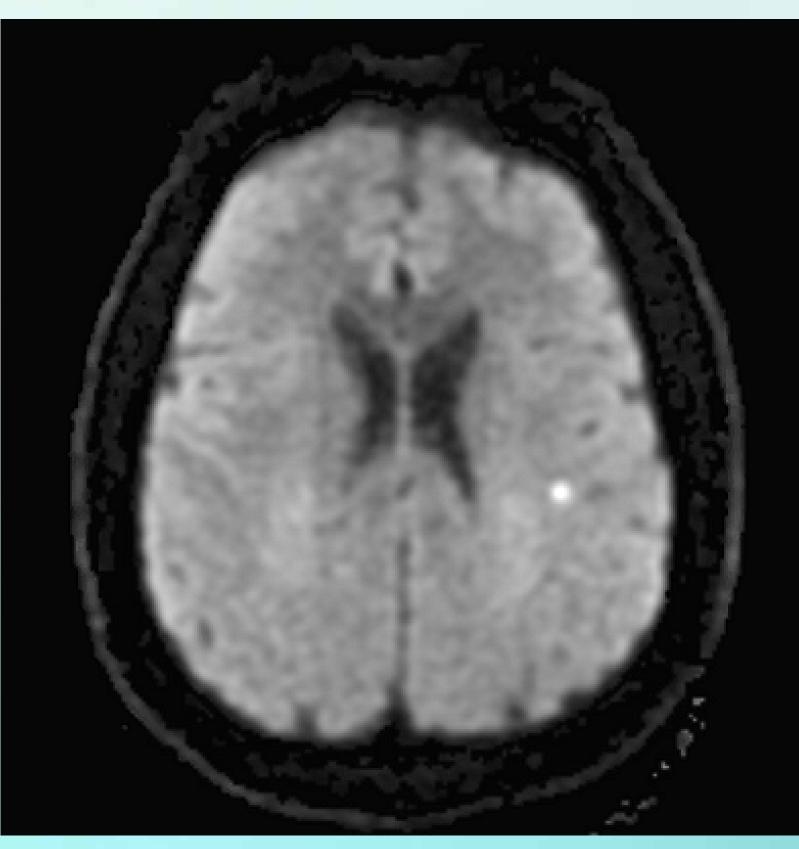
Initial MRI of the Brain which revealed left middle cerebral artery stroke.
